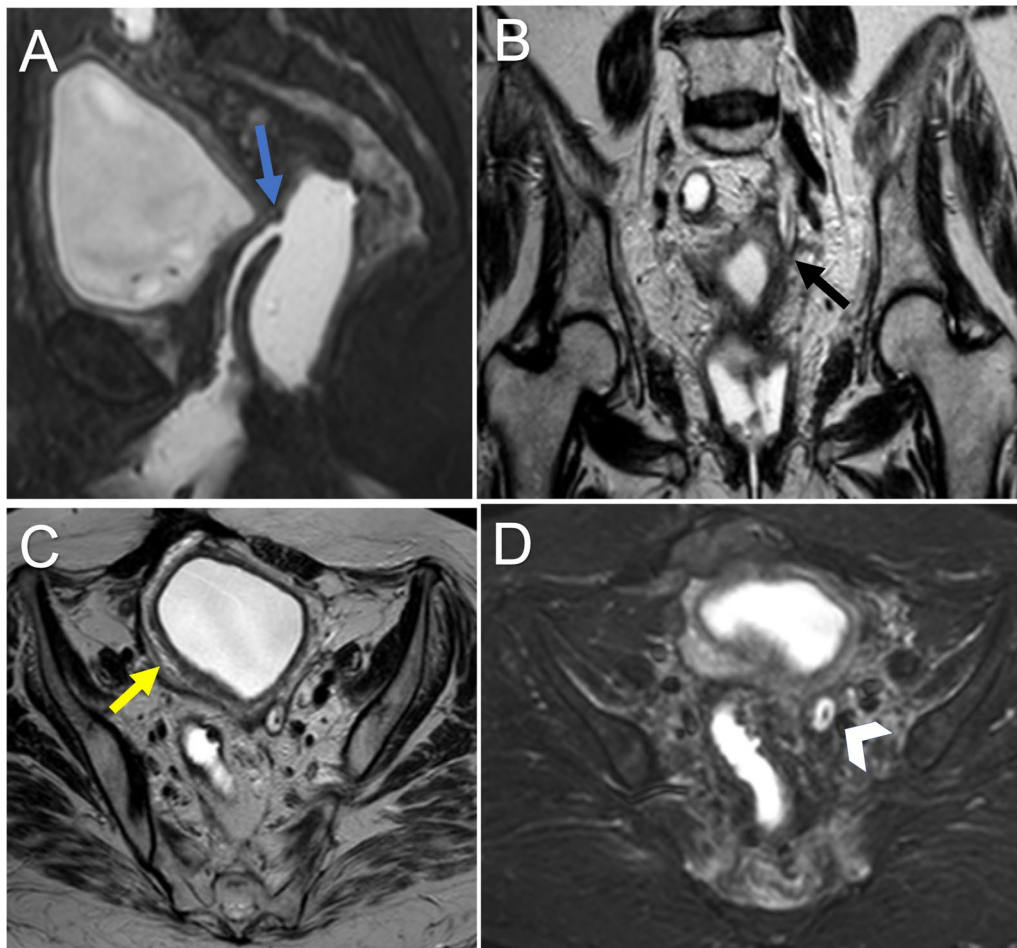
61-year-old female patient with history of colon cancer, underwent surgical resection and ileostomy, received chemo and radiotherapy, complained of vaginal discharge, and was referred for assessment by MRI with administration of rectal gel. A Sagittal STIR weighted image revealed passage of the injected rectal gel to the hysterectomy stump with evidence of fistulous communication (white arrow) seen anteriorly at the mid rectum communicating with the posterior surface of the upper aspect of the hysterectomy stump. B, C and D Coronal T2, axial T2 and STIR weighted images show mild mural thickening and stricture of the left distal ureter (black arrow) and subsequent moderate hydroureter showing in situ double-J stent (arrowhead), mild vesical mural thickening (yellow arrow) and stranding of the peri-vesical fat planes also noted as well as pre-sacral soft tissue sheets (post radiation changes). Accordingly, the surgical management plan was fistulectomy and postponing the stoma reversal
